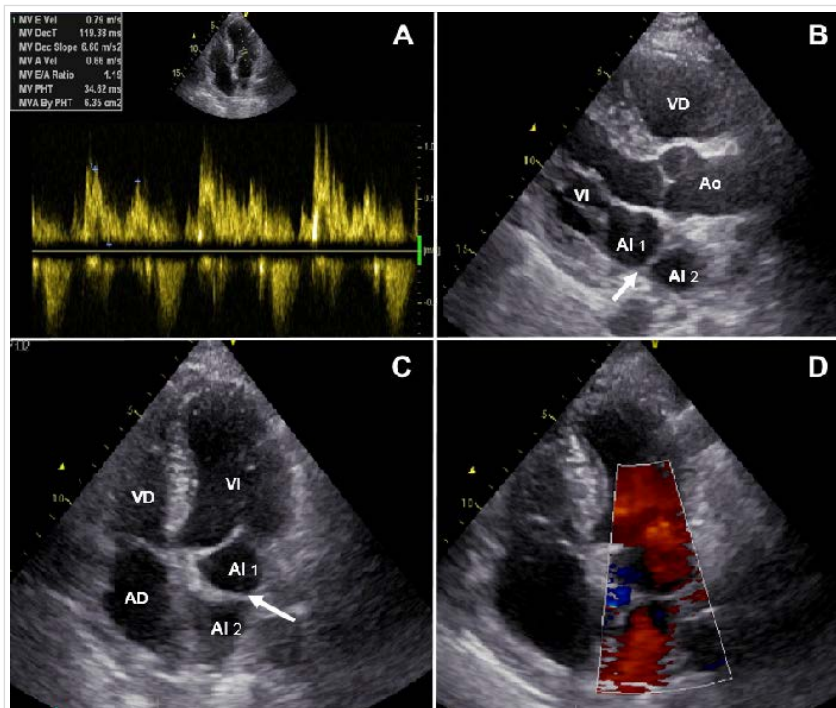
Transthoracic echocardiogram. A. Mitral flow with pulsed Doppler. B. Two-dimensional mode (parasternal long-axis view) with two chambers (LA1 and LA2) divided by the membrane or fibromuscular roll (arrow). C. Apical 4-chamber view showing a typical triatrial heart (*cor triatriatum* - RA, LA1, LA2). Arrow points to membrane in LA. D. Color Doppler image of the left chambers.
